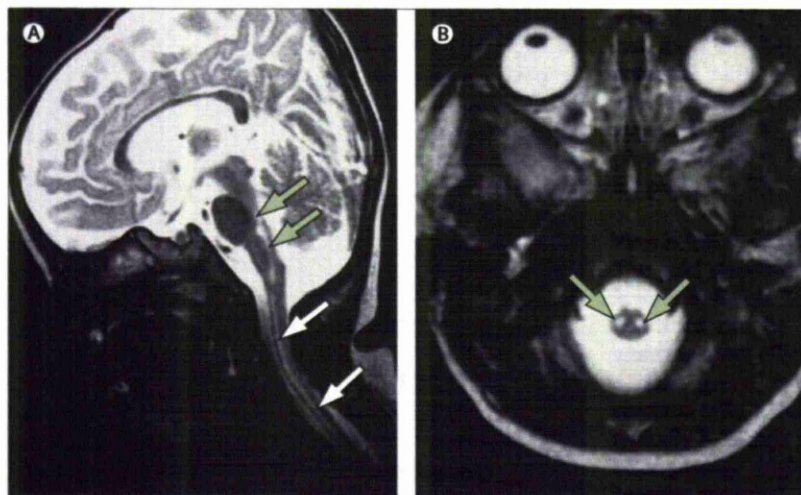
MRI changes in enterovirus-71-associated encephalomyelitis
